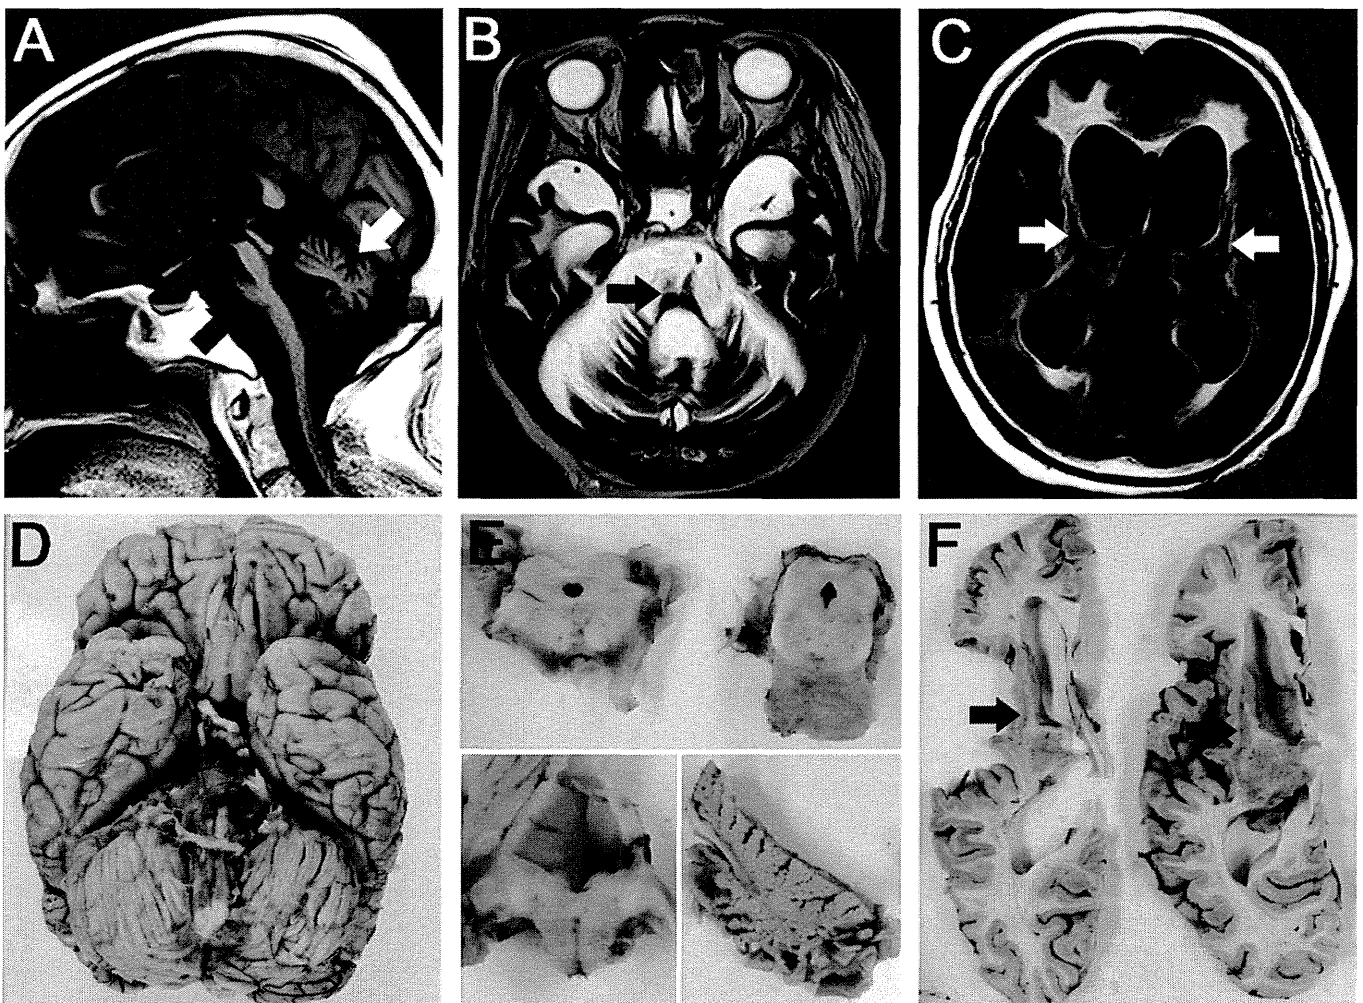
Imaging studies (A–C) and macroscopic views (D–F) of the whole brain of the present case. (A) Severe atrophy of the cerebellum (white arrow) and the brainstem (black arrow) are prominent on T1-weighted MRI. (B) Signal change in the pons (hot-cross bun sign) is noted on T2-weighted MRI (arrow). (C) Fluid attenuated inversion recovery images also reveal cortical atrophy of the fronto-temporal lobe and putaminal atrophy with hypointensity (arrows). (D) From the basal view, there is severe atrophy in the cerebellum and the brainstem with brownish discoloration, and the bilateral frontal lobes are also atrophic. (E) The coronal sections of the brainstem show depigmentation of the substantia nigra, and severe atrophy of the pontine base (upper half), the inferior olive (lower left) and the cerebellum (lower right). (F) The horizontal sections of the cerebral hemisphere demonstrate putamen atrophy with brownish discoloration (arrows).
